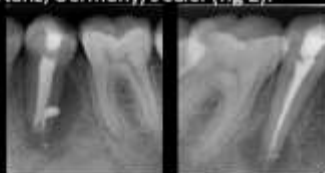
Postoperative final radiographs
